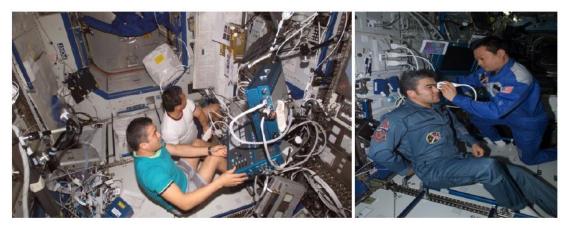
Astronauts using the ultrasound device in the HRF on the ISS (images courtesy of NASA)
